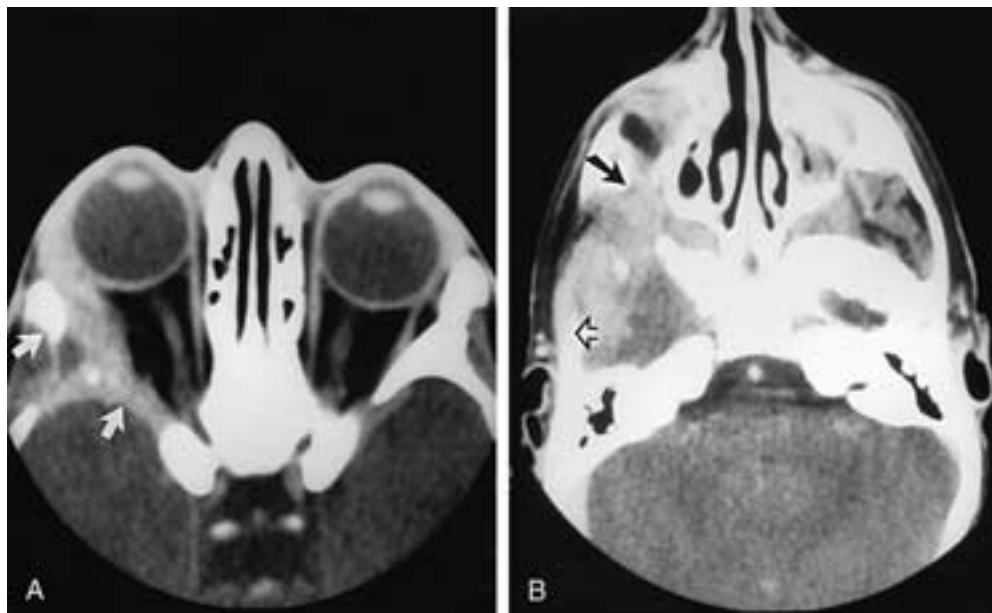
A, Langerhans' cell histiocytosis. Four-year-old boy with a history of gradual proptosis, diabetes insipidus, and skin lesions consistent with Hand-Schüller-Christian disease. Postcontrast axial CT scan shows replacement of the greater wing of the sphenoid bone (arrows) by soft tissue, which demonstrates marked enhancement. B, Langerhans' cell histiocytosis. Postcontrast axial CT scan in the same patient as in A showing a destructive lesion involving the squama of the right temporal bone (hollow arrow) as well as the posterior wall of the right maxillary sinus (solid arrow). Notice the marked soft-tissue infiltration into the right temporal fossa (hollow arrow). (From Hidayat AA et al. Langerhans' cell histiocytosis and juvenile granuloma of the orbit. *Radiol Clin North Am* 1998;36:1229–1240.)
